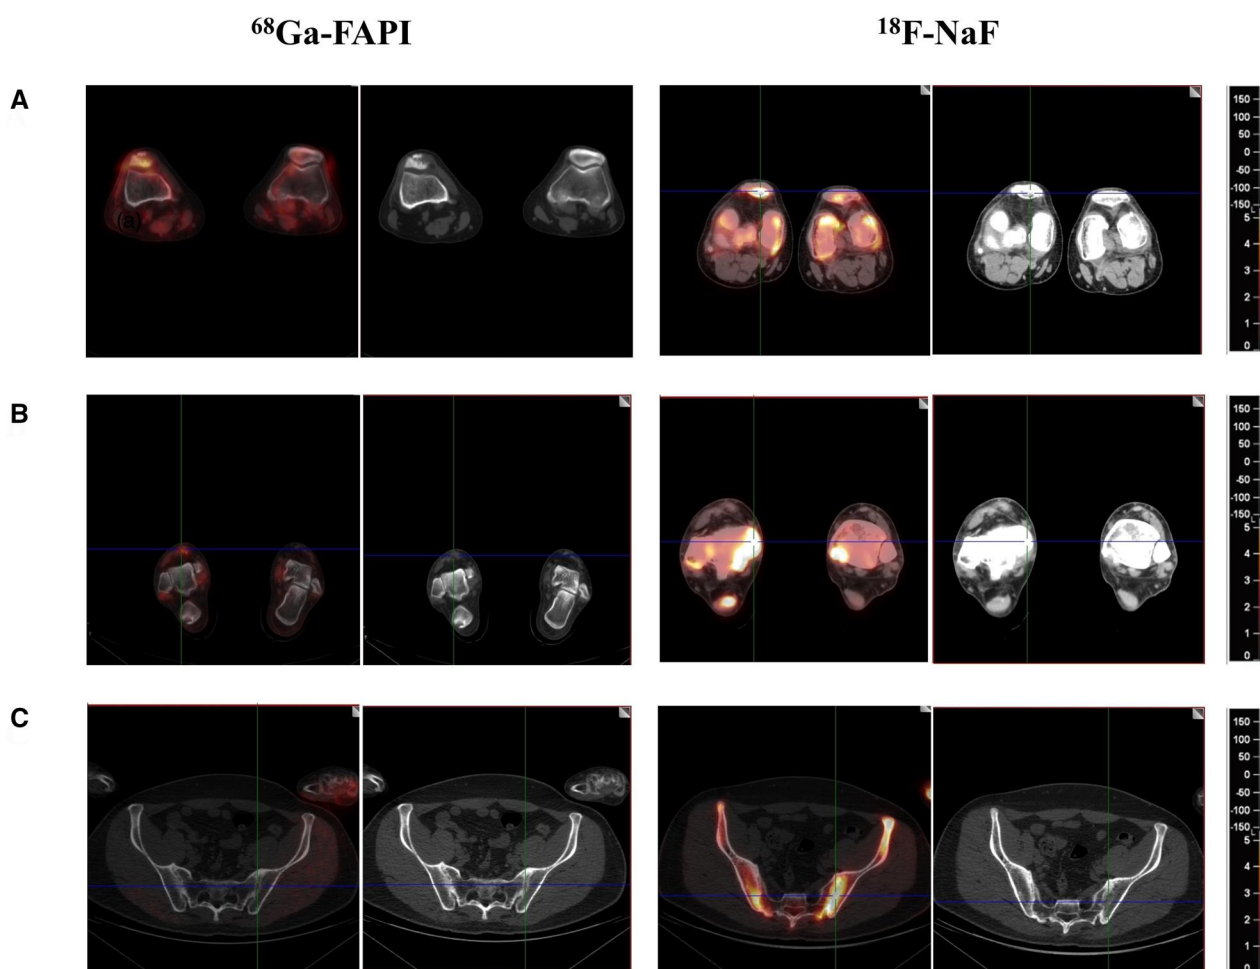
⁶⁸Ga-FAPI and ¹⁸F-NaF fusion (left side) and co-registered CT images (right side) in patient #5, who is a 65-year-old man with a 31-year history of PsA. (A) Moderate-to-intense uptake of both tracers in the right knee joint. (B and C) Higher uptake intensity of ¹⁸F-NaF than that of ⁶⁸Ga-FAPI PET/CT in the Achilles tendon insertion and SI joints
